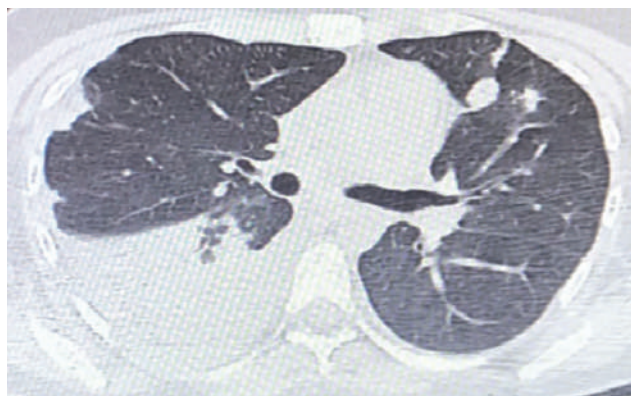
Computed tomography of a patient's lungs (description in text)
